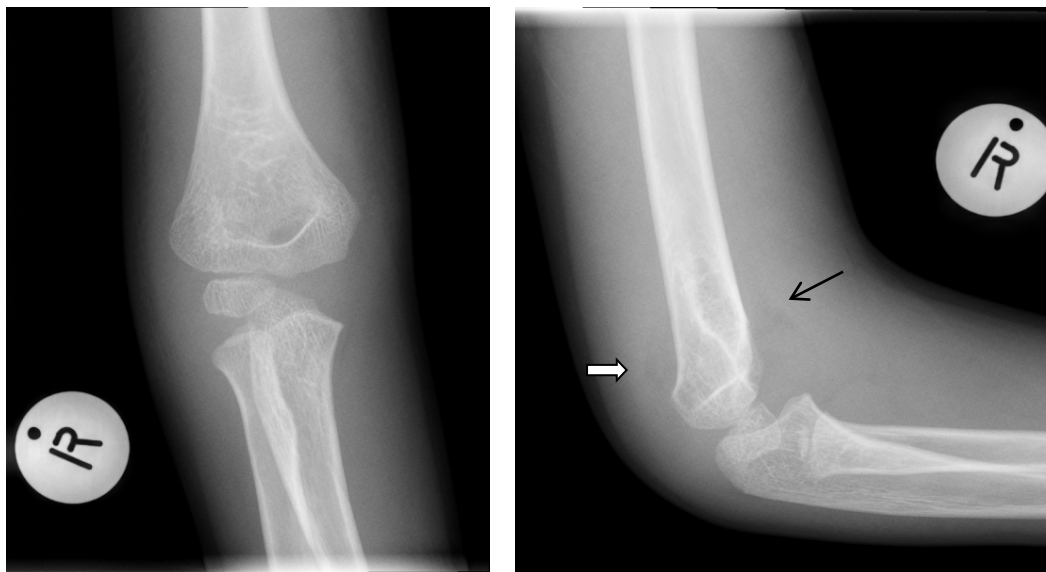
AP and lateral radiograph with soft tissue swelling and joint effusion.
